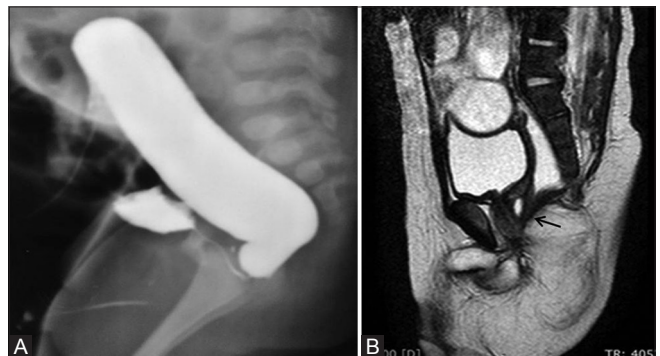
(A and B): 18-month-old male child. (A) Distal cologram (DC) shows high rectourethral fistula. (B) T-weighted sagittal MRI image clearly depicting anatomy as hypointense fistulous tract (arrow) leading from the rectal pouch to the lower prostatic part of urethra
